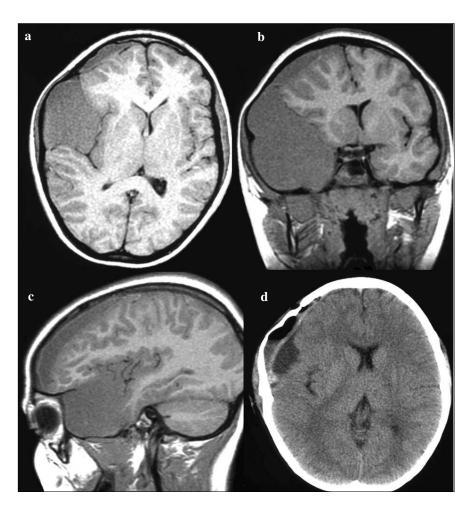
Axial (a), coronal (b) and sagittal (c) magnetic resonance imaging T1-weighted images show the cystic lesion in the right middle cranial fossa with high signal intensity, controlaterally displacing the midline and the lateral ventricles. Furthermore, subdural fluid-blood levels in the right frontal and parietal areas are observed. Postoperative computerized tomography (d) shows the absence of subdural haematoma and the residual cyst with no intracystic bleeding and mass effect
